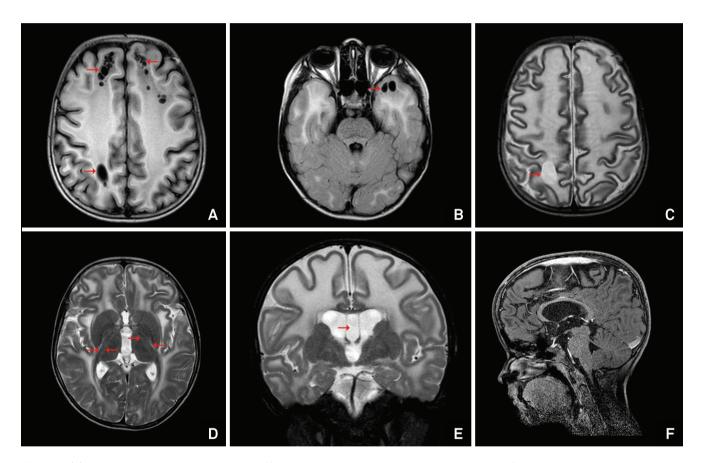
(A), Axial T1-weighted image shows diffuse cerebral white-matter abnormalities with frontoparietal subcortical cysts (arrows). (B), Axial FLAIR image exhibits subcortical cysts (arrows) in the anterior temporal lobe intermingled with diffuse white-matter hyperintensity. (C) and (D), Axial T2-weighted images with diffuse white-matter abnormalities, the external and extreme capsules are involved and the posterior limb of the internal capsule shows a double-line of abnormal intensity (arrows in D). (E), Coronal T2-weighted image highlights a diffuse brain swelling with white-matter hyperintensity and persistence of the cavum septum pellucidum (arrow). (F), Sagittal T1-weighted image with fat suppression and after endovenous gadolinium contrast, note the cranio-facial disproportion without abnormal enhancement. The corpus callosum is relatively spared.
